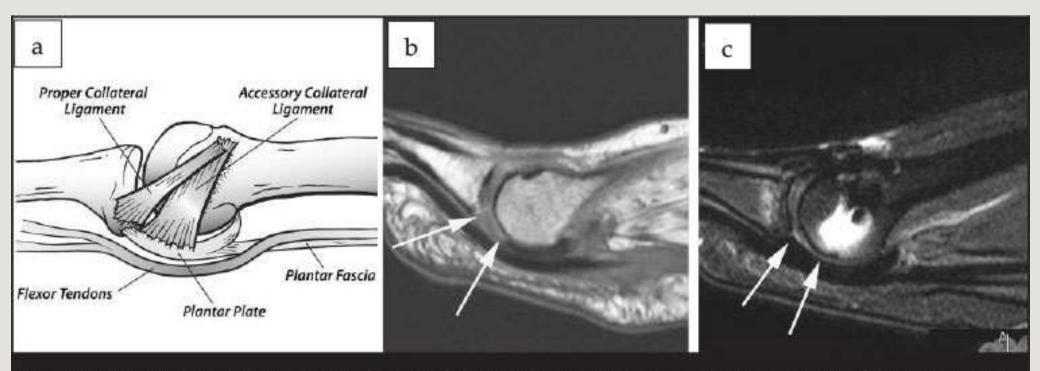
a) MTP plantar plate anatomy; b) MRI of plantar plate tear; c) MRI 12 months post successful repair. Note the artefact from Weil osteotomy screw fixation
